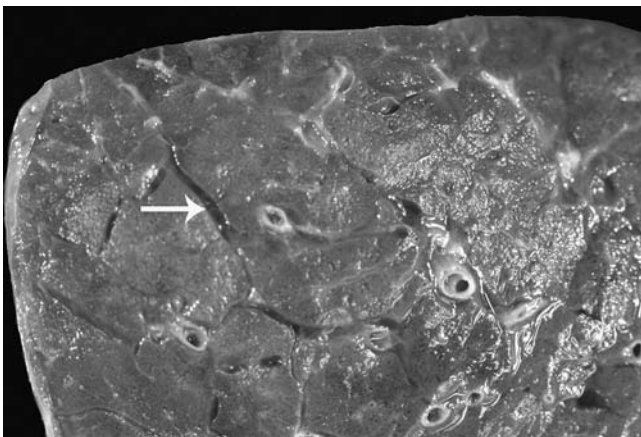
Part of a lung slice from a patient with hydrostatic edema, showing dilated interlobular septa (one at *arrow*), some extending to pleura (corresponding to Kerley B lines on a chest radiograph).
